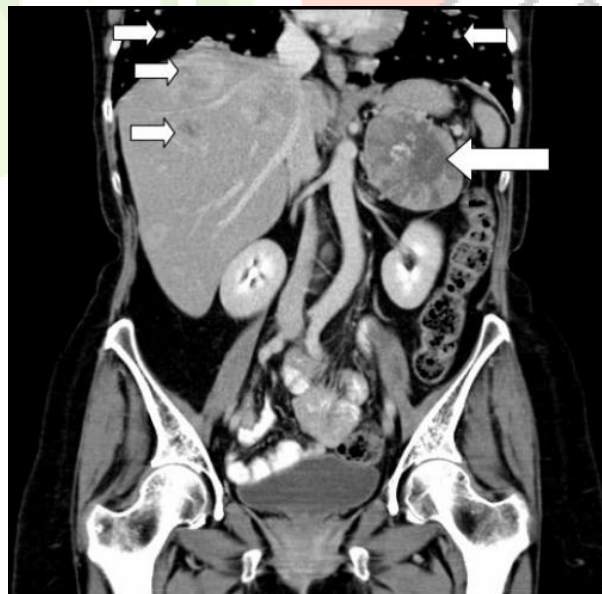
CT of a large inhomogeneous ACC of the left adrenal gland with multiple pulmonary and hepatic metastases.
